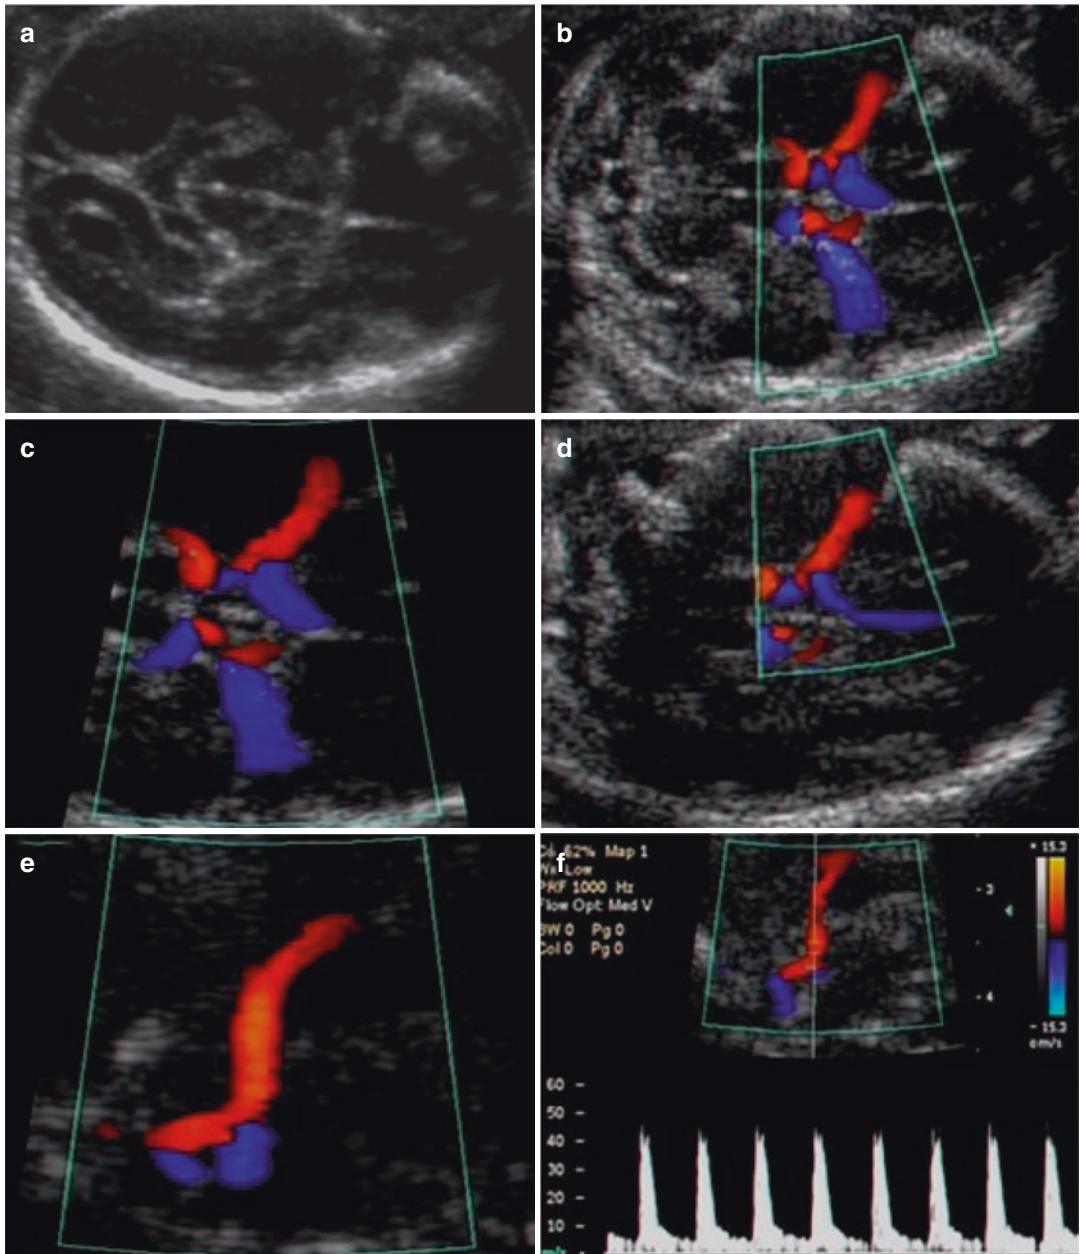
Steps for correct MCA sampling. Top left, Axial section of the head at the level of the sphenoid bones; top right, color Doppler evidence of the circle of Willis; center left, the circle of Willis is enlarged; center right, the color box is placed around the MCA; bottom left, the MCA is zoomed and an angle off insonation as
